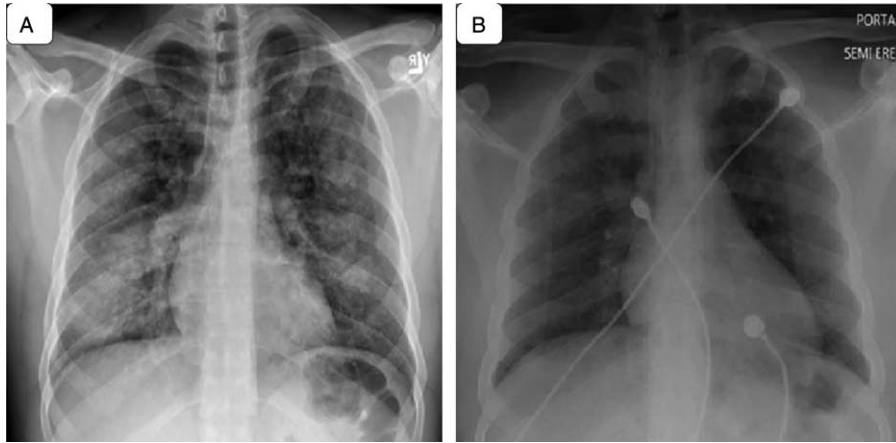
Patient's chest radiograph upon admission (A) and on discharge (B).
